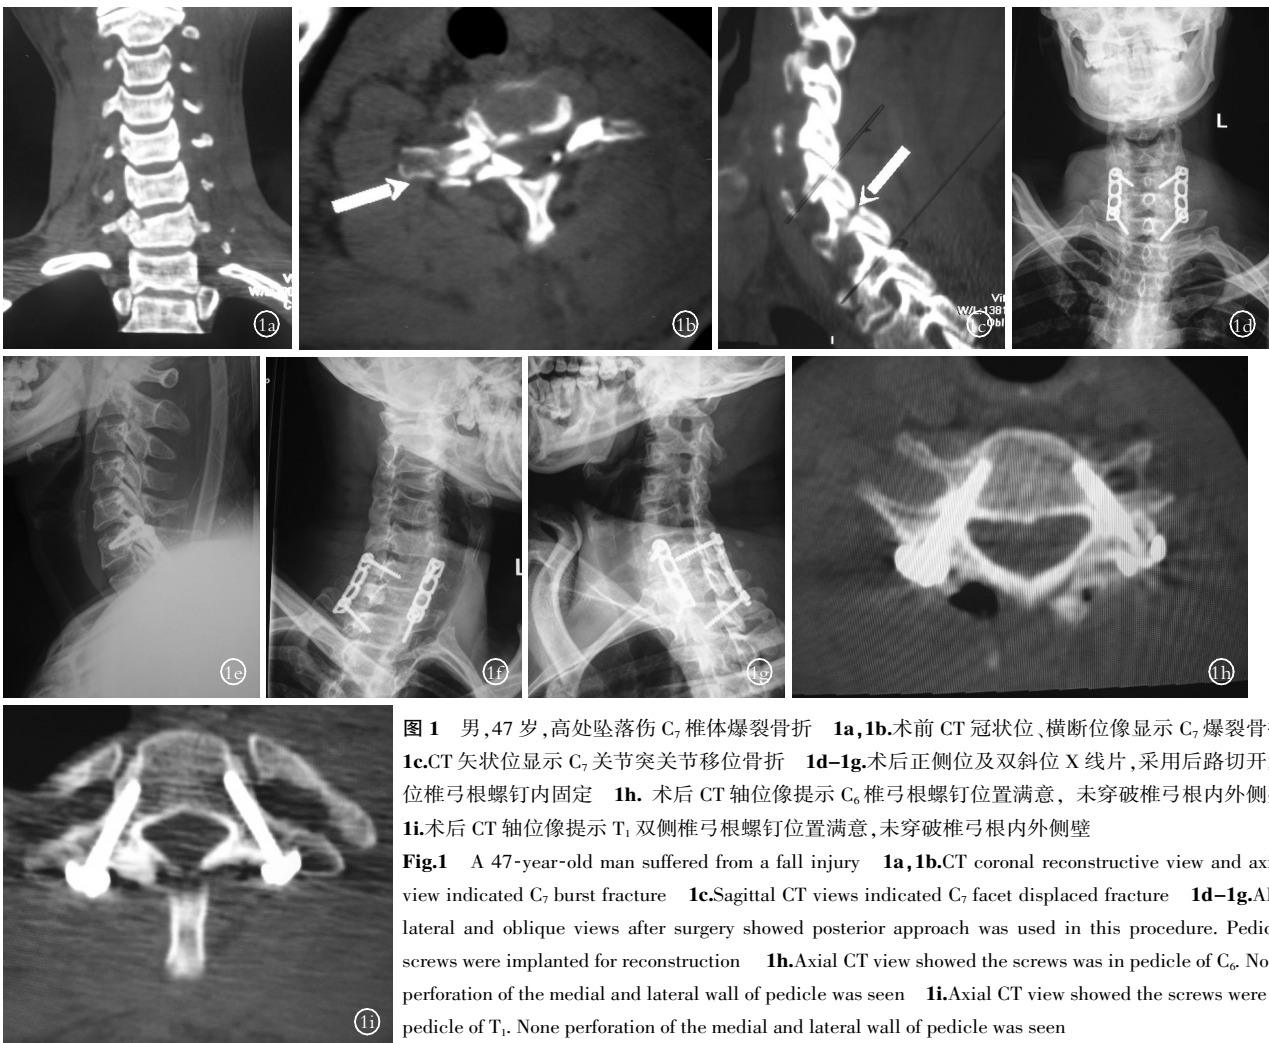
男,47 岁,高处坠落伤 C₇ 椎体爆裂骨折 1a,1b.术前 CT 冠状位、横断位像显示 C₇ 爆裂骨折 1c.CT 矢状位显示 C₇ 关节突关节移位骨折 1d-1g.术后正侧位及双斜位 X 线片,采用后路切开复位椎弓根螺钉内固定 1h.术后 CT 轴位像提示 C₆ 椎弓根螺钉位置满意,未突破椎弓根内外侧壁 1i.术后 CT 轴位像提示 T₁ 双侧椎弓根螺钉位置满意,未突破椎弓根内外侧壁
